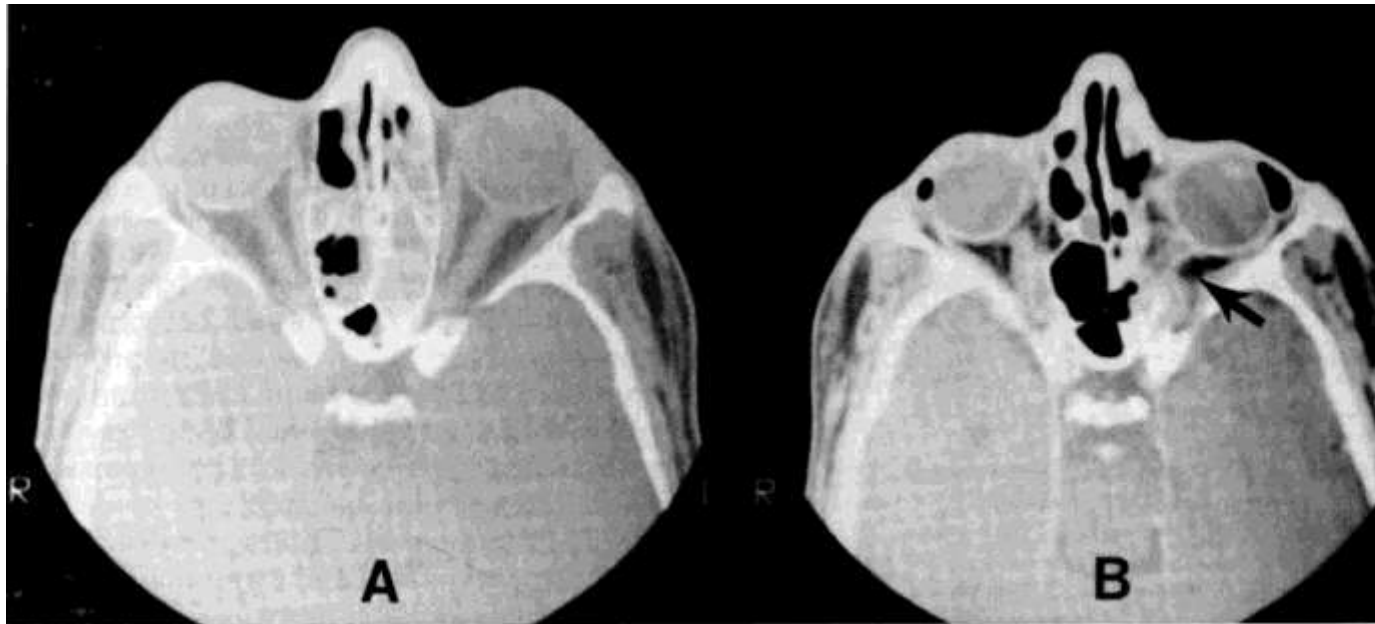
Patient 2. CT scan (axial plane). A. Intact optic nerves, preoperatively. B. Both lamina papyracea are damaged. Optic nerve on the right is anatomically intact, but completely severed on the left (arrow).
